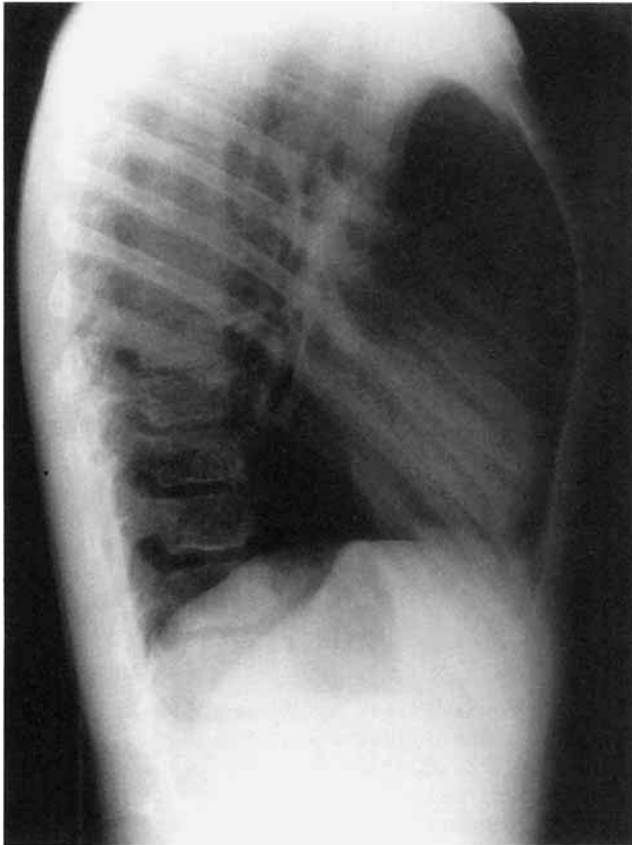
Patient 2: age 11½ years. Lateral dorsal spine radiograph. A mild upper dorsal kyphosis is present. There is mild anterior "humping" of the superior and inferior end plates of the lower dorsal and upper lumbar vertebrae. Scoliosis was present (not shown).
